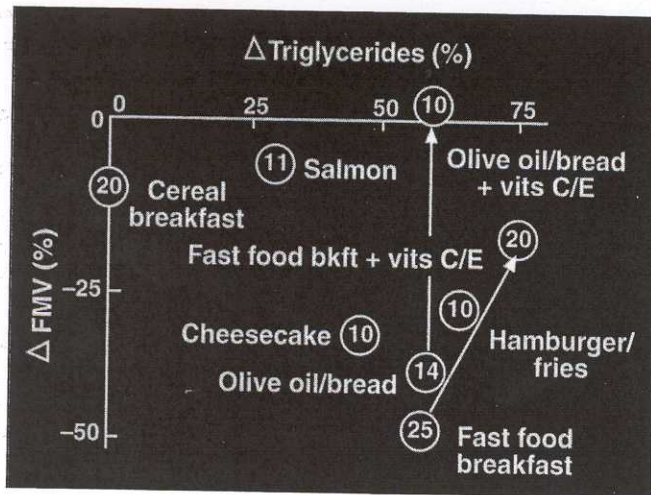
Effect of lipid challenge in normal individuals. Three-hour postprandial changes in triglycerides and flow-mediated vasodilation (FMV) after specific meals. Changes are expressed on the y axis as percentage changes versus baseline (prechallenge) FMV. Pretreatment with vitamin E (800 U) and vitamin C (1 gm) restores FMV toward normal values despite fat ingestion. vits, vitamins; bkft, breakfast. (From Vogel R. Brachial artery ultrasound: a noninvasive tool in the assessment of triglyceride-rich lipoproteins. *Clin Cardiol* 1999;22[Suppl II]:1134–1139, with permission.)
